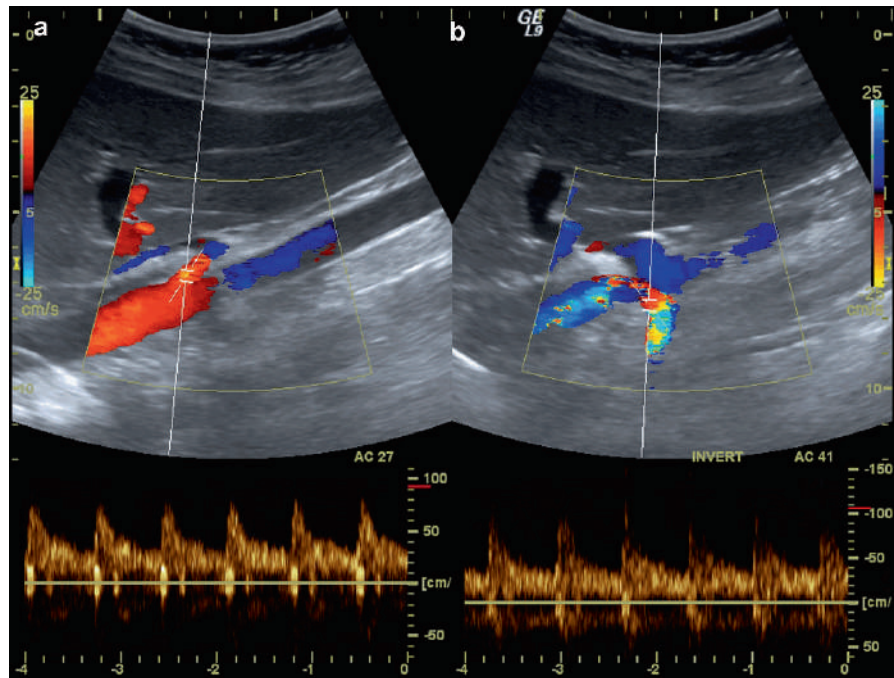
Color Doppler sonogram of the left kidney demonstrates its vascular anatomy in (b) and arterial waveform detection in (a) to assess the arterial vascular supply as an indirect method for detecting RAS
